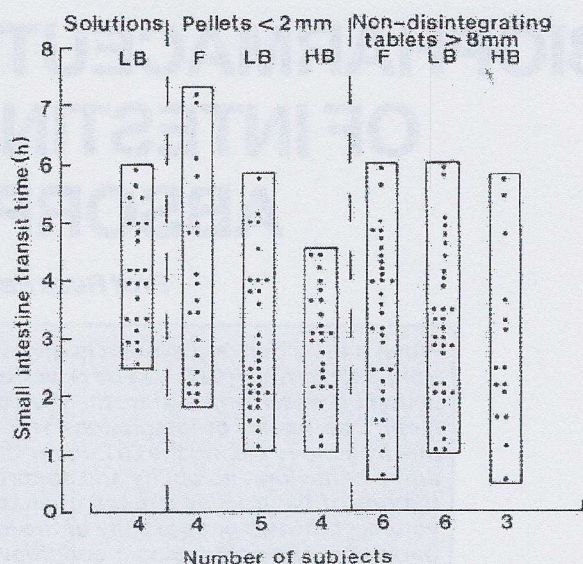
Range of individual data points observed in subjects studied for intestinal transit time of pharmaceutical dosage forms according to feeding conditions using gamma scintigraphy
